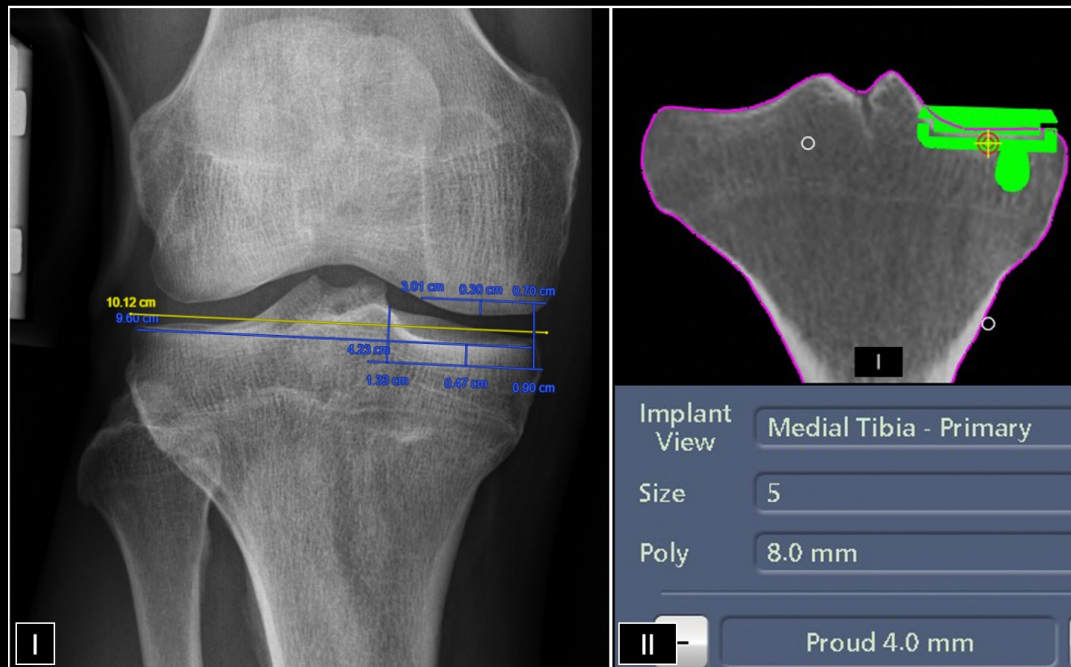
Comparison of tibial bone resection measured on valgus stress x-rays with the information provided intraoperatively by the robot.
